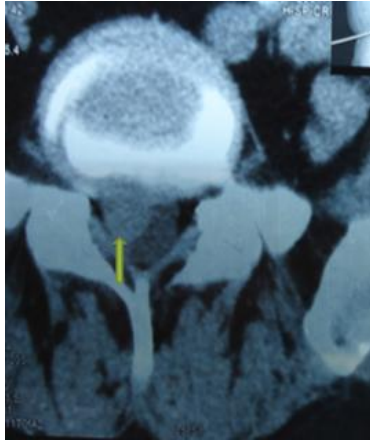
CT image of disc herniation at L₅-S₁ level
